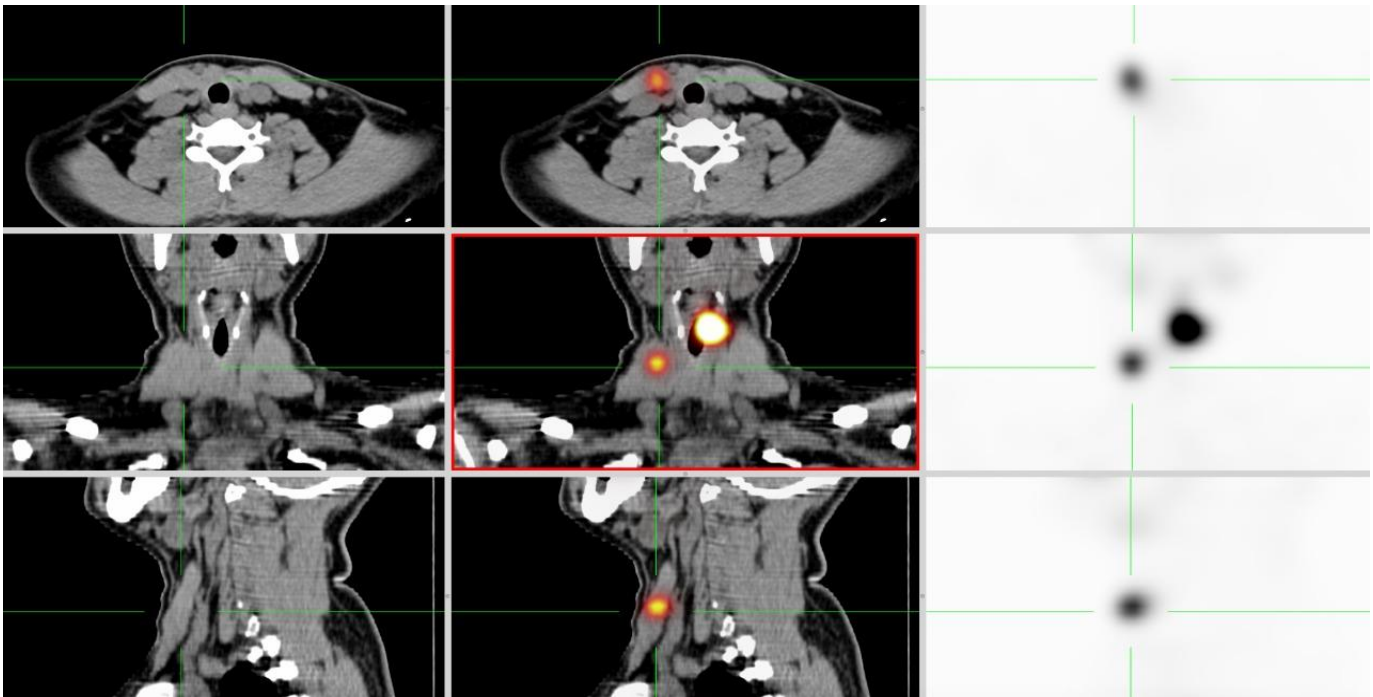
Thyroid scan with SPECT/CT images demonstrating intense radioactive isotope uptake at implant location with residual functioning thyroid tissue
